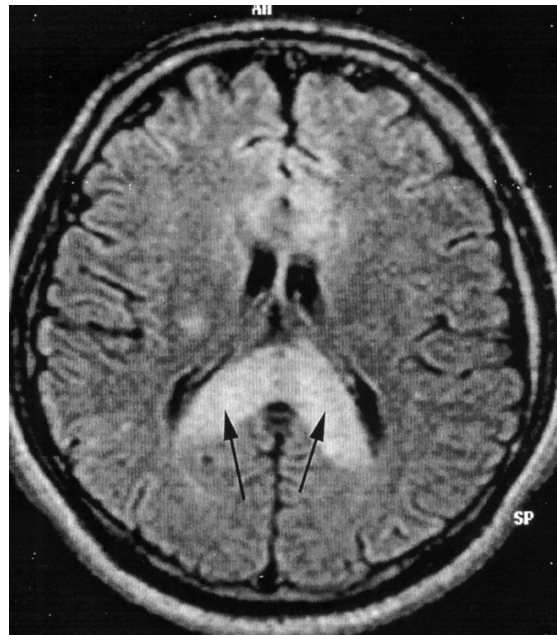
MRI showing marked swelling and hyperintense posterior body and splenium of corpus callosum on T2 image (dark arrows) in a HACE case that went on to full recovery. Image courtesy of Dr. Buddha Basnyat.
